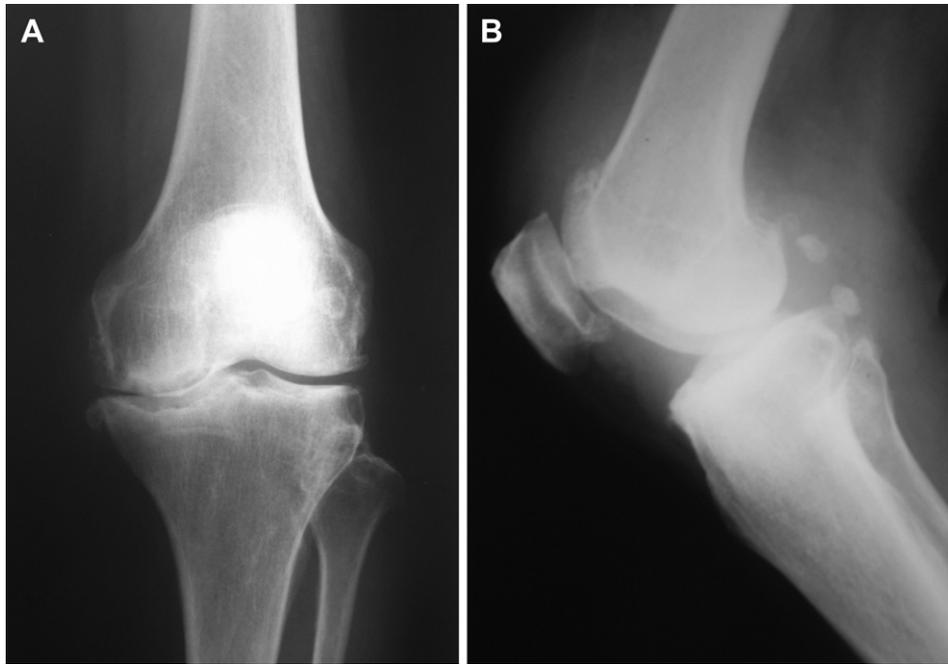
Preoperative X-rays of the left knee.
